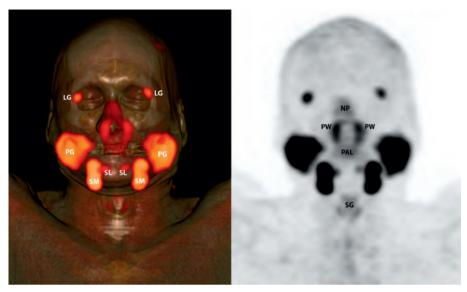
Anterior projection overview of combined PSMA PET/CT (left) and PSMA PET (right), showing tracer uptake in healthy salivary, seromucous, and lacrimal glands in a patient with prostate cancer and no apparent metastatic disease. LG, lacrimal gland; NP, nasal and nasopharyngeal mucosa; PW, pharyngeal wall; PAL, soft palate; PG, parotid gland; SM, submandibular gland; SL, sublingual gland; SG, supraglottic larynx.
